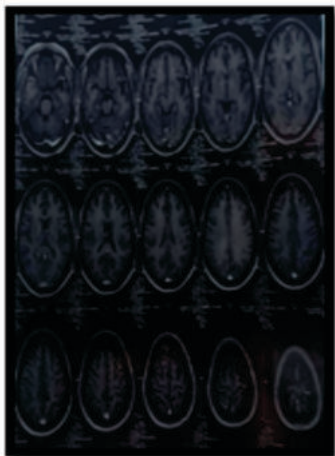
MRI images revealed a focal mass lesion that exhibited heterogeneous enhancement.
